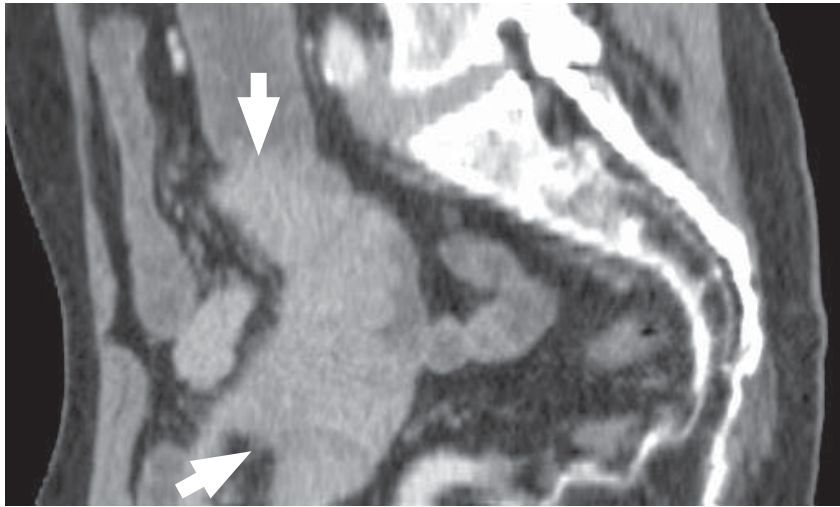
The CT of the whole abdomen with contrast enhancement, sagittal section shows an intestinal mass at wall of jejunum (see arrows) with proximal jejunal dilatation. There is no evidence of regional node enlargement.
